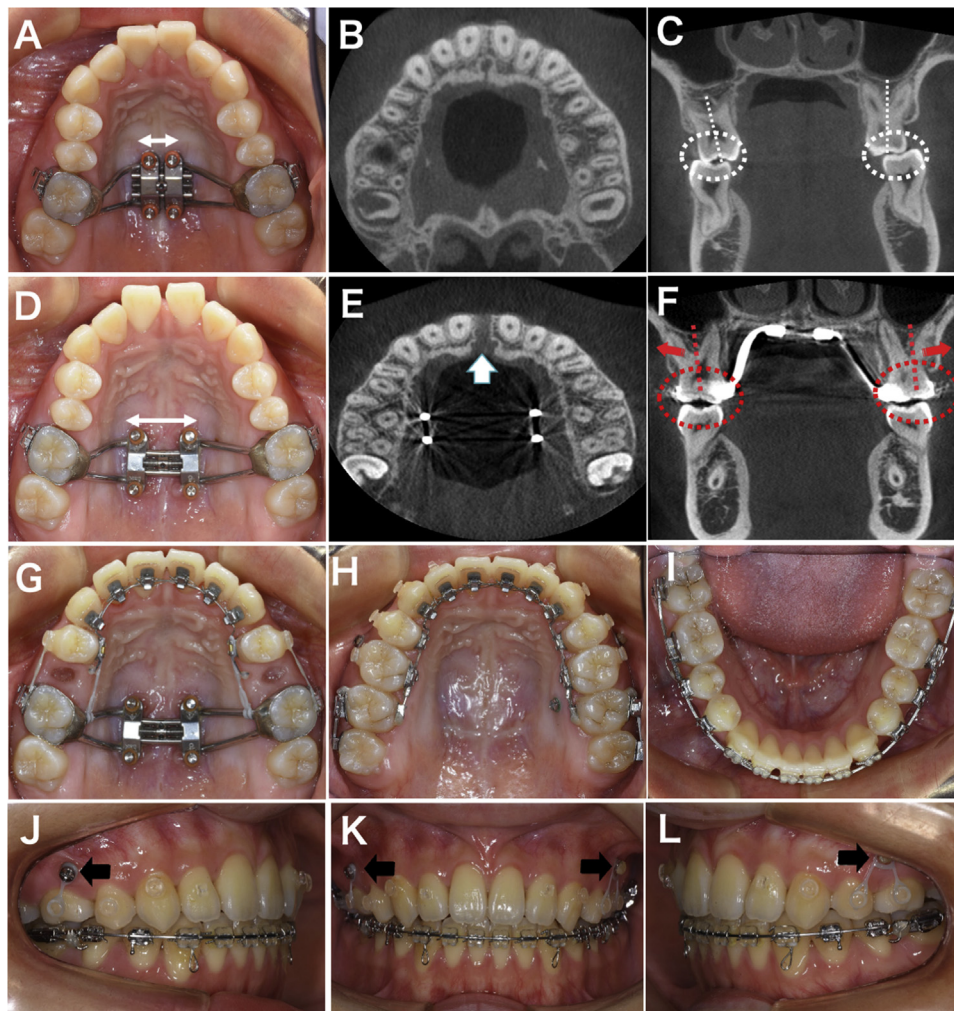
Patient 1: photographs and CBCT images of maxillary skeletal expansion. A-C, Before expansion the preactivated screws (A, arrow; B and C, CBCT coronal and sagittal images showing molar tipping with a crossbite; C, dotted circle and lines); D-F, after expansion photograph, coronal CBCT (E, arrow) and sagittal CBCT images (F, red, direction of expansion; red, change in molar angulation); G, intraoral photographs of the initial stage of retracting the premolars using the MSE as anchorage; H and I, after retraction of the maxilla and the mandible; J-L, miniscrews were used to control the vertical dimension in the maxillary molars (black).
